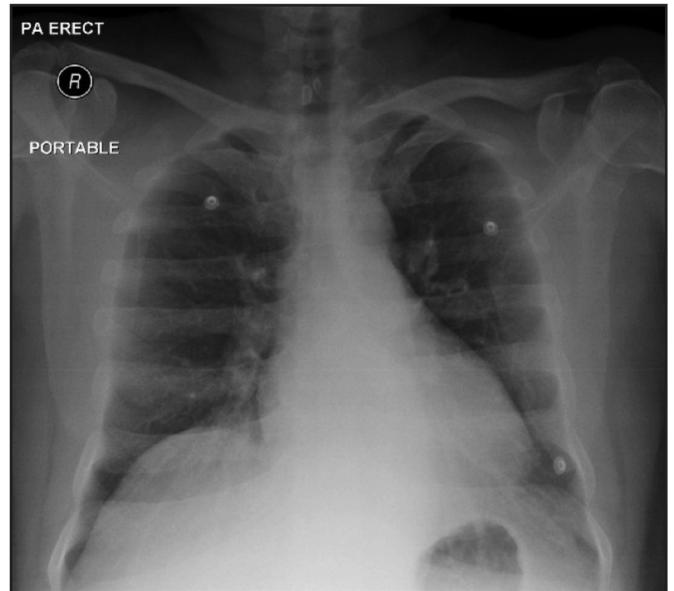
Chest X-ray showing ground glass opacities with interstitial infiltrates over bilateral lung fields.
